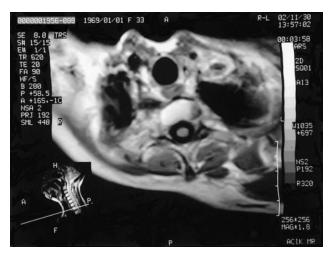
Axial MRI section, 44 months after calcitriol treatment.
